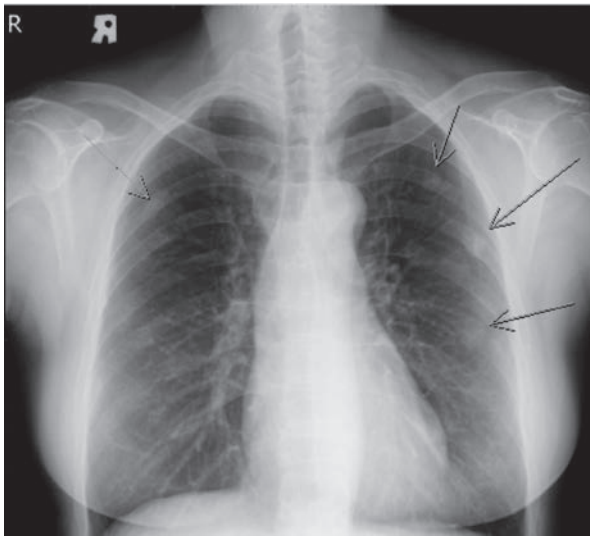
(a) Chest X-ray shows bilateral old ribs fractures. (b) Pelvis X-ray reveals a new fracture of left superior/inferior pubic ramus.
